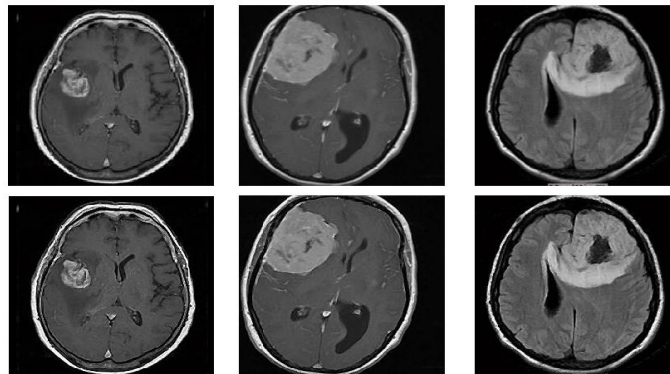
Pre-processed MR images of the brain with a brain tumor
